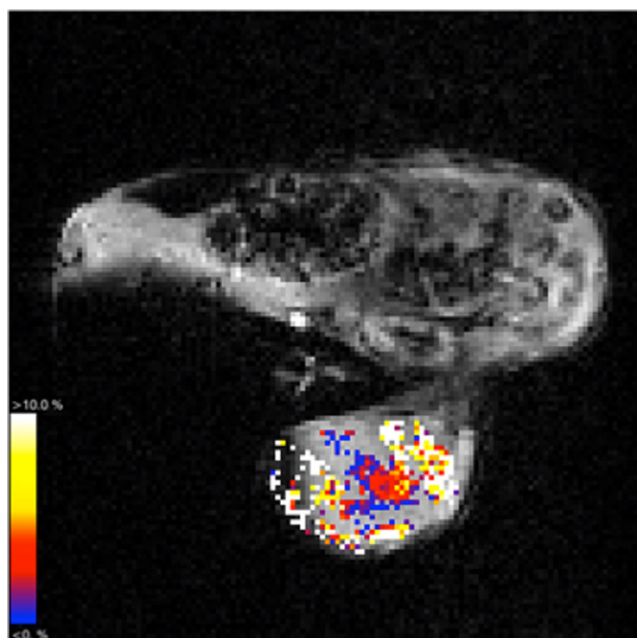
rBV map acquired from a 786-O RCC xenograft using susceptibility-contrast MRI with USPIO particles
